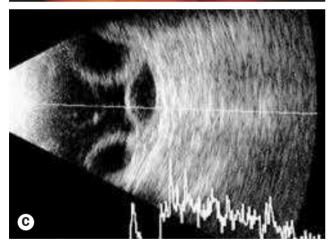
(A) Positive Seidel test; (B) wide-field image of choroidal detachment; (C) ultrasound of choroidal detachment in a hypotonous eye
